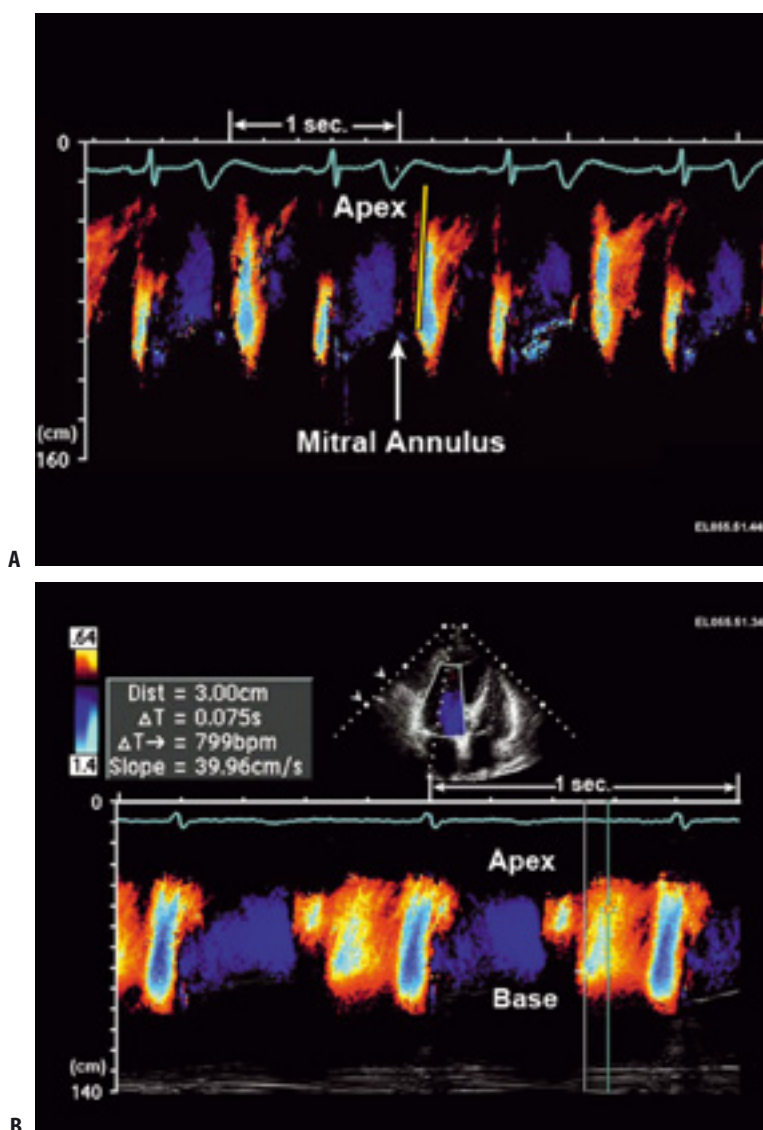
(A) Normal color flow propagation velocity of mitral inflow indicated by the yellow slope. (B) Color flow M-mode echocardiogram of mitral inflow velocity from a normal individual. Color flow map baseline was shifted upward to decrease the positive aliasing velocity. The manipulation of the color flow map allows demonstration of the highest velocity of the early diastolic
